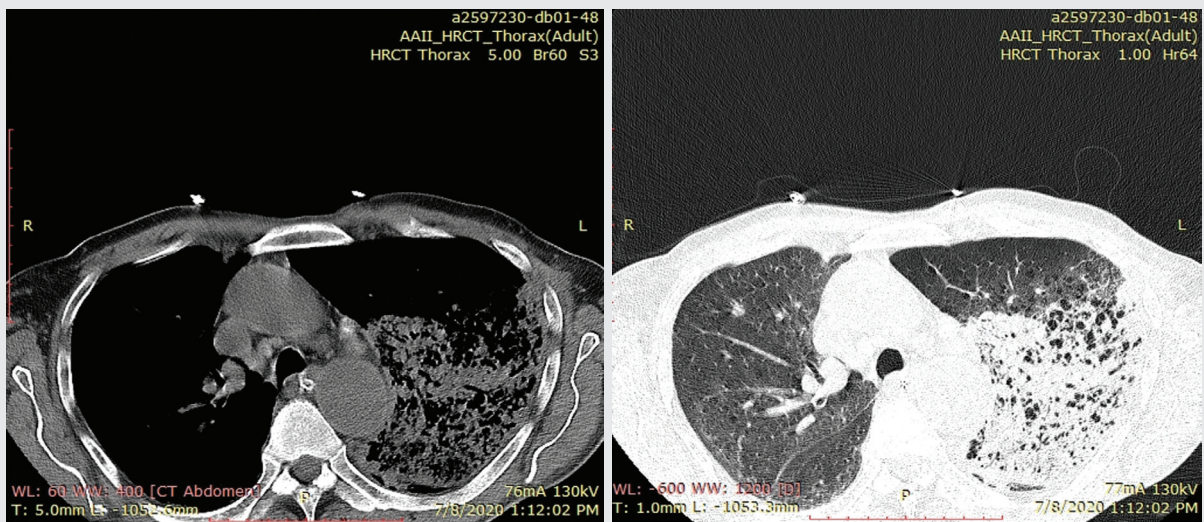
HRCT chest pulmonary and mediastinal window showing patch of consolidation in the background of emphysematous changes giving swiss cheese appearance
